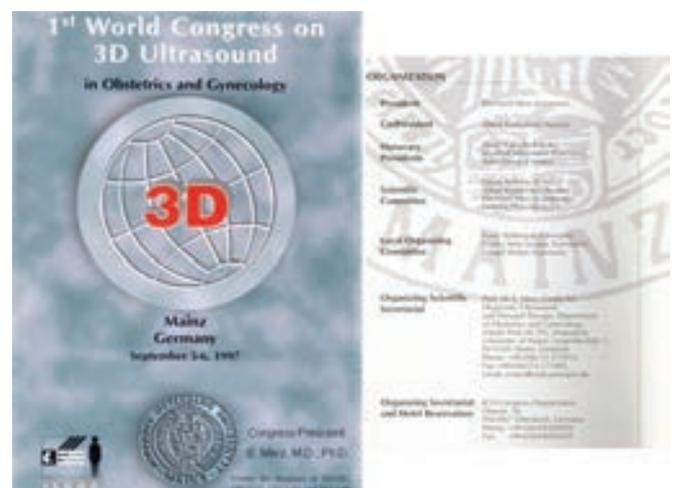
Announcement of the first World Congress on 3D ultrasound held on September 5 to 6, 1997 in Mainz, Germany
